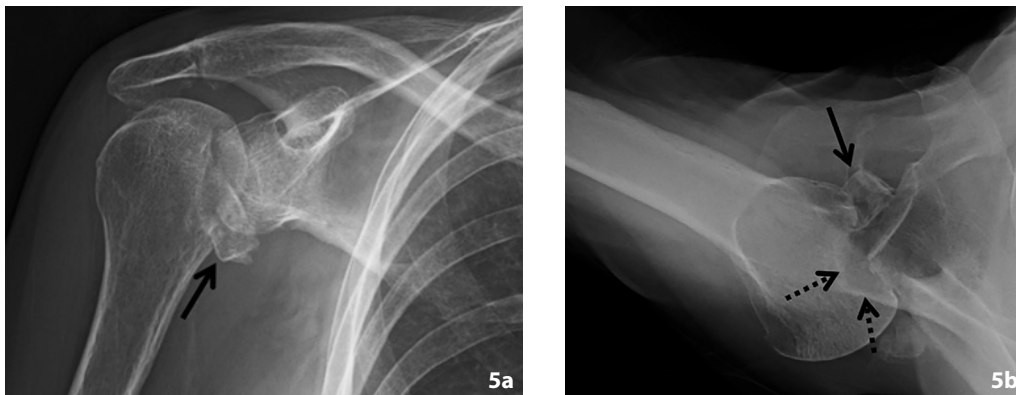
Sharply defined “veil of obscuration” radiographic sign. (a) AP internal rotation radiograph of the right shoulder shows a comminuted lesser tuberosity fracture (solid arrow) creating the sharply demarcated “veil of obscuration” radiographic sign. (b) Axillary radiograph of the same shoulder demonstrates a displaced fracture of the lesser tuberosity (solid arrow). Also note the humeral head is dislocated posteriorly in relation to the glenoid with large reverse Hill-Sachs lesion at the anteromedial aspect of the humeral head (dashed arrows).
